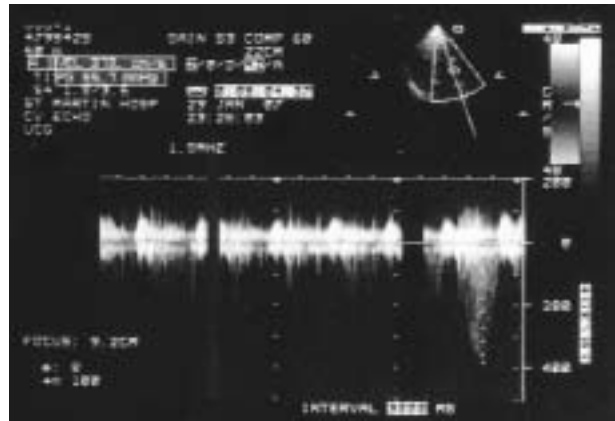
Echocardiography demonstrated a pressure gradient of 55 mmHg between the right atrium and ventricle and it indicated severe pulmonary hypertension of at least 60 mmHg.
